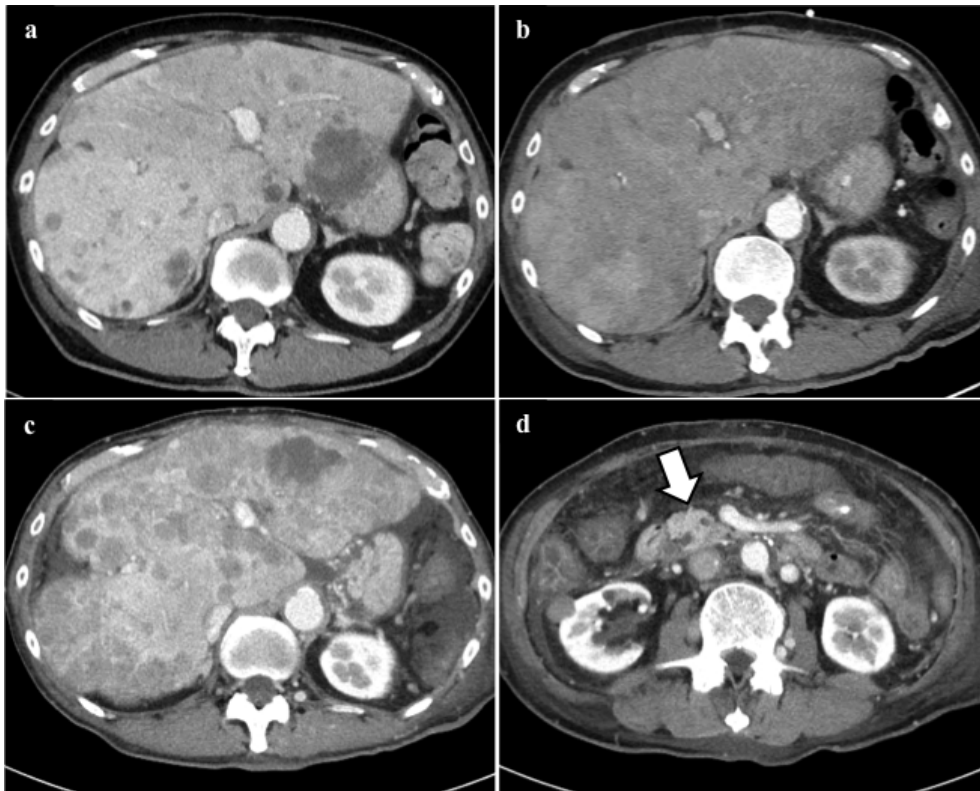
Temporal change in liver metastases visualized on abdominal computed tomography (CT).
